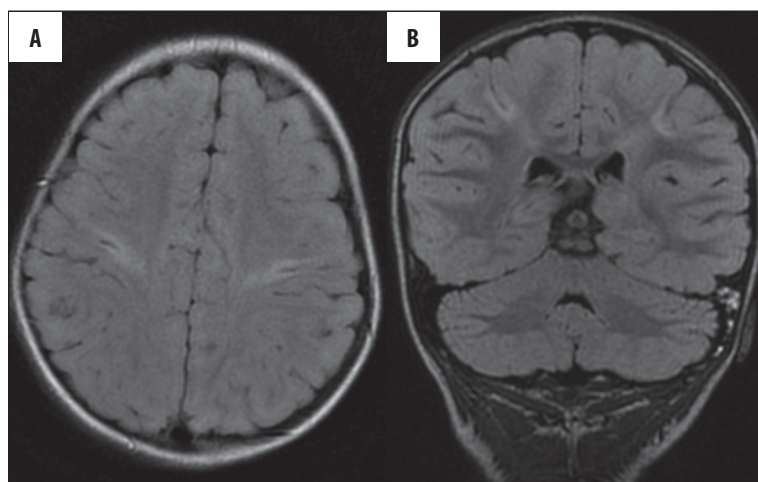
Cerebral cortex and white matter injury in a term newborn after acute asphyxia. (A) FLAIR,ax; (B) CUBE/3D/FLAIR,cor.
